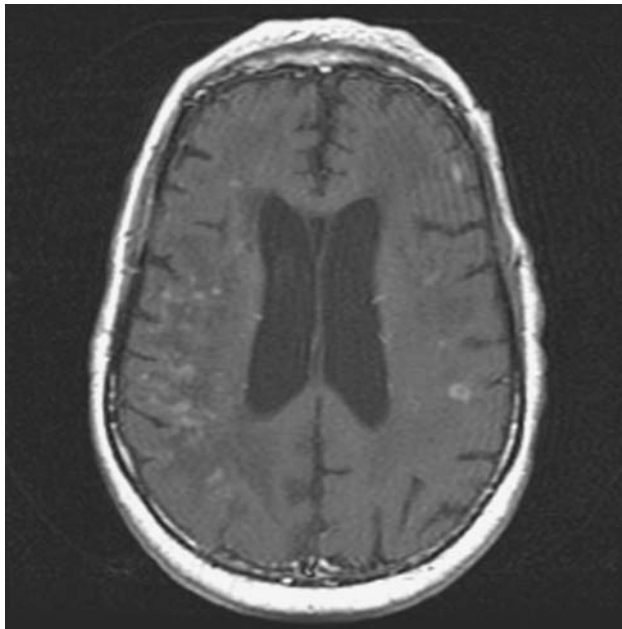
T1 MRI of the brain after Gadolinium enhancement showing multiple small enhancing lesions within the perivascular spaces in both hemispheres
